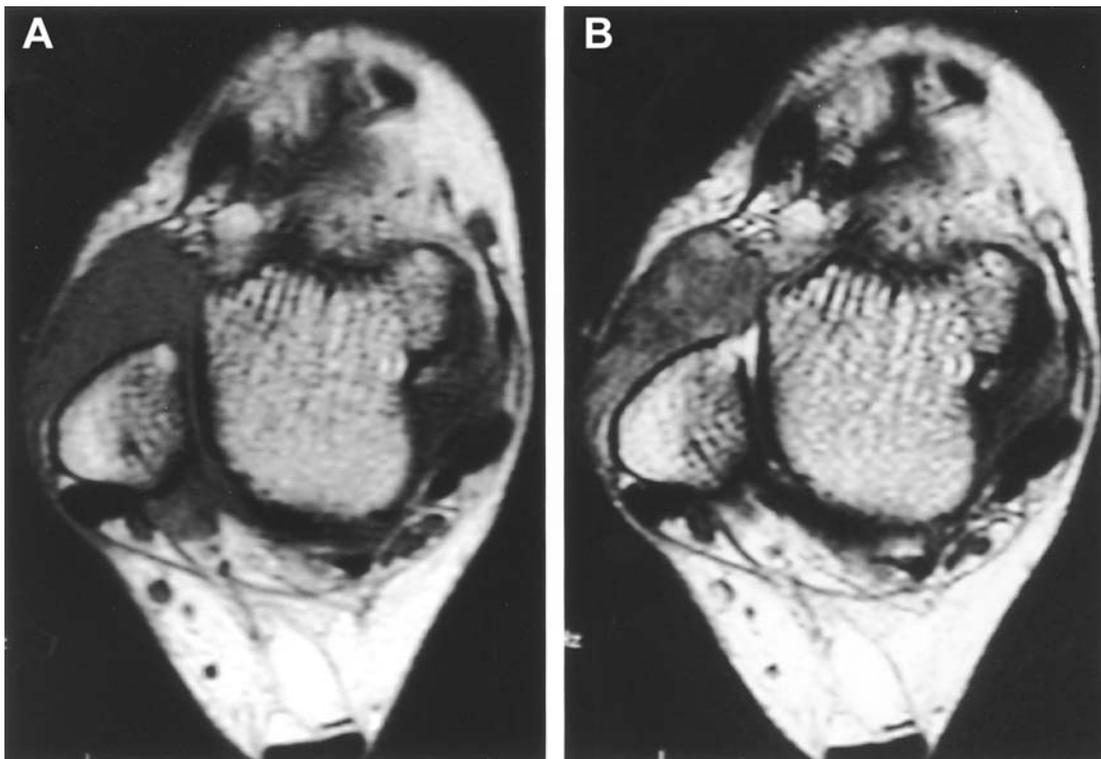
Magnetic resonance image (MRI) axial section. T1-weighted image shows low signal intensity lesion adjacent to lateral malleolus (A). T2-weighted image shows low and high intensity lesion. The low intensity area may represent the lesion of melanin pigmentation.
